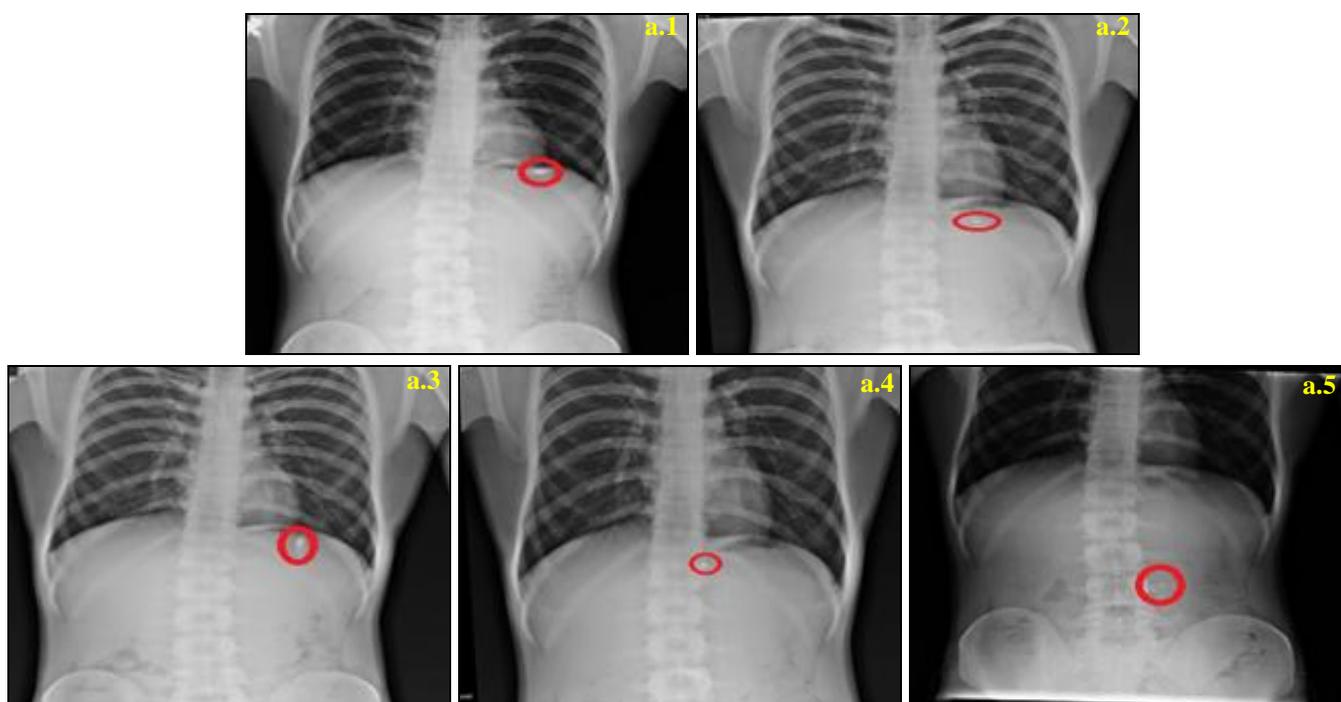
RADIOGRAPHIC IMAGES ARE SHOWING THE PRESENCE OF $BaSO_4$ -LOADED FLOATING CAPSULES IN THE GIT AT DIFFERENT PERIODS IN FED CONDITION. THE CAPSULES ALTERED ITS POSITION IN THE STOMACH. Images were taken at: a.1) 1 h, a.2) 2 h, a.3) 4h, a.4) 6h and a.5) 8hr after capsule administration (n=2 subjects).
